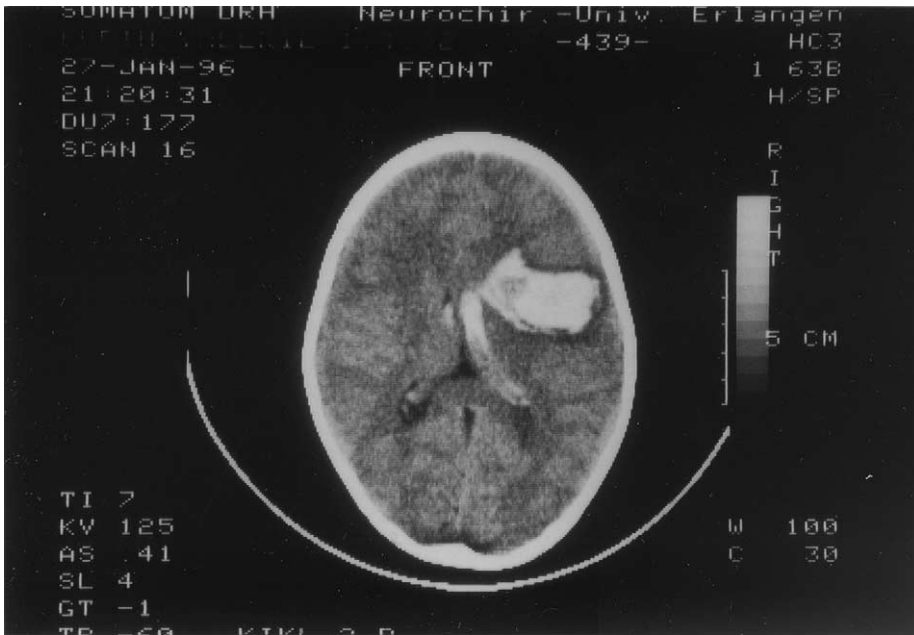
Cranial computed tomography on the day of admission demonstrating extensive intracerebral hemorrhage in the right frontotemporal region.
